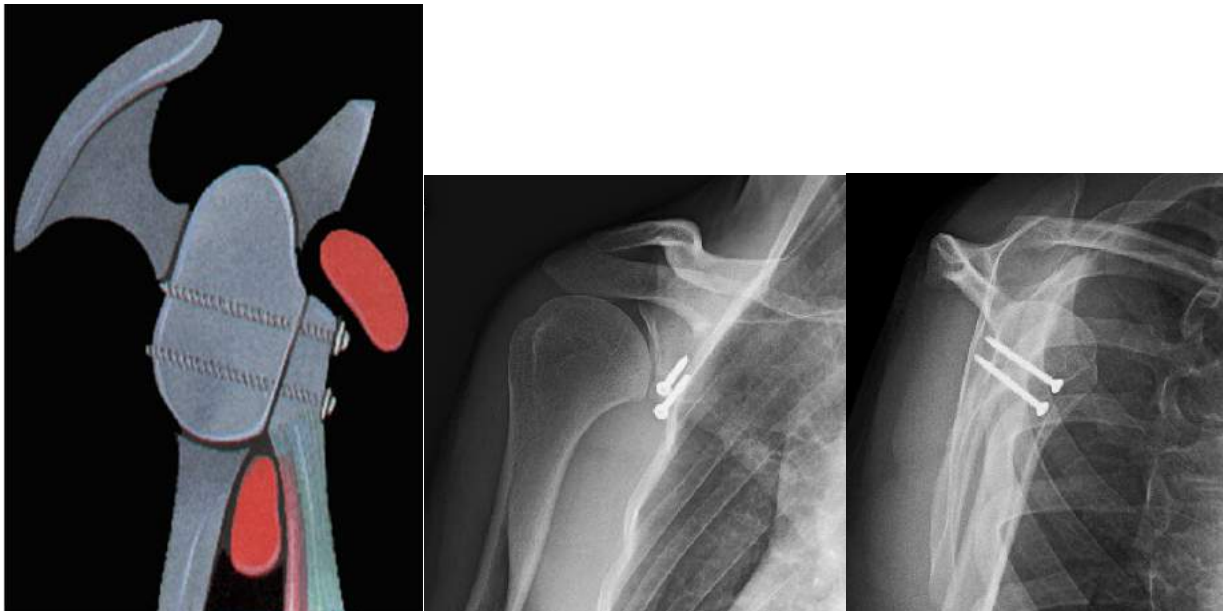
(left) The coracoid has been transferred to the bottom of the shoulder socket and screwed in place. Center and Left: Post-operative AP and Lateral X-Ray of a healed Latarjet.
